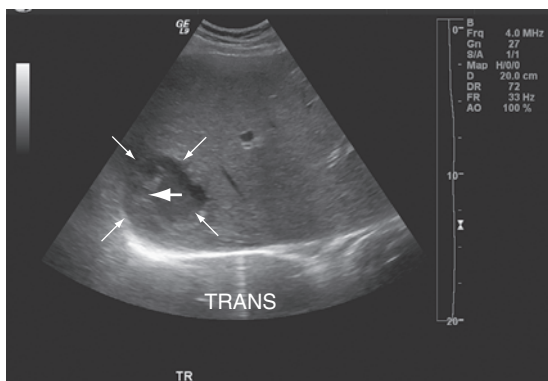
Amebic abscess. (A) A transverse sonogram showing an amebic abscess (between white arrows) in the right lobe of liver. Note the presence of diffuse low-level echoes and a thick septation (small white arrow).
